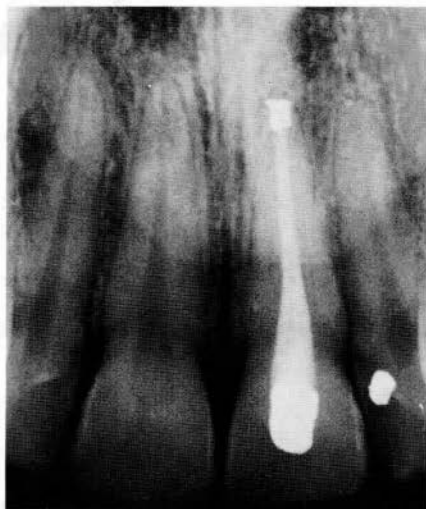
After more than 3½ years, the radiographic picture confirms the clinical observation: a maxillary left central incisor, normal in appearance, with no apparent pathology present
